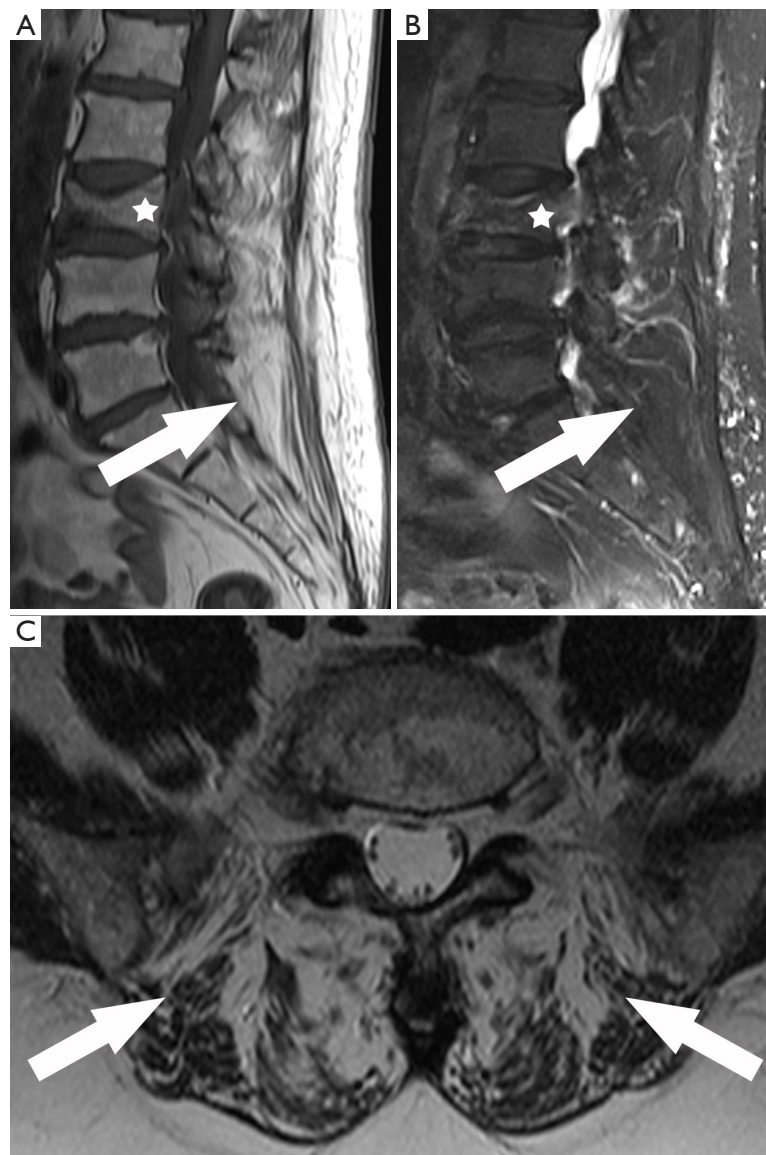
Association between osteoporosis and vertebral fracture. Sagittal T1-weighted (A), sagittal T2-weighted (B) with fat suppression, and axial T2-weighted MRI (C) of a 75-year-old woman. Non-recent vertebral osteoporotic fracture at L3 [star in (A) and (B)] is detected together with fatty degeneration of paraspinal muscles [arrows in (A), (B) and (C)].
